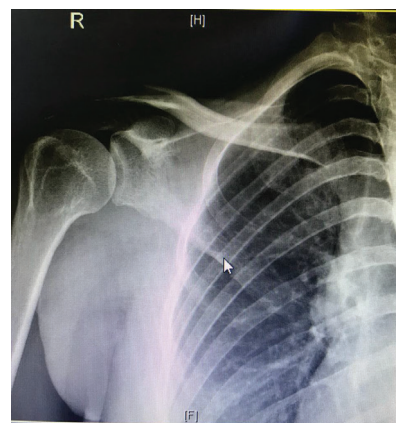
X-ray right shoulder – normal.
